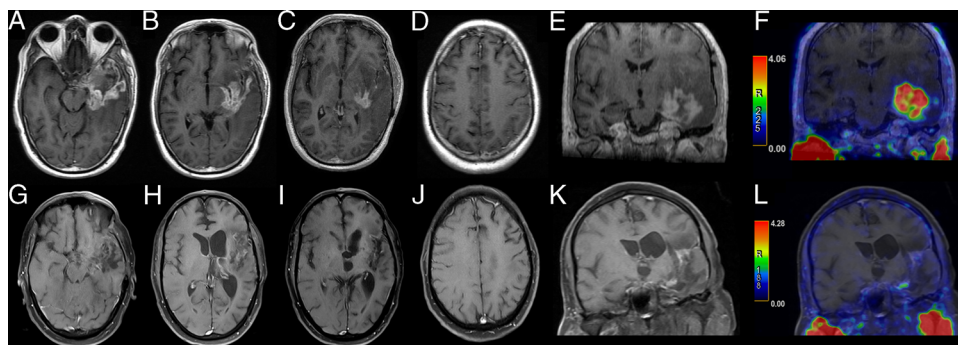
A 37-year-old man treated for left temporal glioblastoma multiforme (GBM) with total tumor excision, radiotherapy, and adjuvant temozolomide presented with headache, seizures, and progressive right-sided weakness within 1 month of therapy completion. Serial MRI showed progressive left temporal nodular enhancing lesion extending to involve left gangliocapsular region posteriorly with perilesional edema and leptomeningeal enhancement (A–E). After being refused surgery and radiation therapy and financial constraints limiting bevacizumab therapy, the patient was taken up for ^{68}Ga -prostate-specific membrane antigen (^{68}Ga -PSMA-11) PET. Fused ^{68}Ga -PSMA PET/MR images demonstrated intense PSMA expression in the enhancing areas on MRI (F). Written and informed consent of the patient was obtained, and he underwent 3 cycles of 3700 MBq ^{177}Lu -PSMA-617 therapy at 2 monthly intervals with no significant adverse events in the post-treatment period. The patient showed improvement in performance score (ECOG 4 to 3) and symptoms. Post-therapy MRI (G–K) and fused PET/MR (L) showed significant reduction in lesion size (volume decreased from 18 to 5.4 mL using brain tumor image analysis, <https://www.nitrc.org/projects/bratemia> software) with minimal residual enhancement and PSMA expression with no new lesion elsewhere. Recurrent glioblastoma is associated with a poor prognosis, limited treatment options, and a median survival of 12 to 15 months.^{1,2} The expression of PSMA has been demonstrated in neovasculature of high-grade gliomas,^{3–5} and ^{68}Ga -PSMA-11 PET has been suggested as a useful imaging option in recurrent GBM.^{6,7} As PSMA is highly overexpressed in prostate cancer cells, successful targeted radioligand therapy with ^{177}Lu -PSMA-617 has been reported in cases of brain metastases from the carcinoma prostate.^{8,9} Because no further therapy options were available to our case, we offered him ^{68}Ga -PSMA-11 followed by ^{177}Lu -PSMA-617 theranostics, which resulted in symptomatic improvement and good imaging response. This case therefore demonstrates the potential for ^{177}Lu -PSMA theranostics in recurrent GBM. Further multicentric studies with prospective data collection would be useful to determine the usefulness of this salvage option in this aggressive disease with high mortality.
